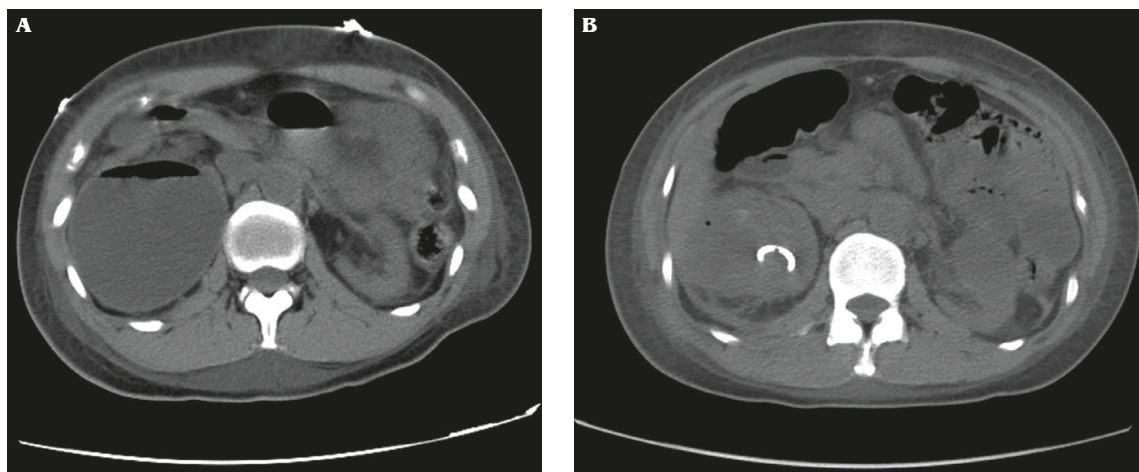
(A) Unenhanced computed tomography of the abdomen at the time of diagnosis shows air accumulation within a subcapsular collection at the posterior aspect of the enlarged right kidney. (B) A percutaneous catheter was inserted into the subcapsular collection of the right kidney for drainage.
